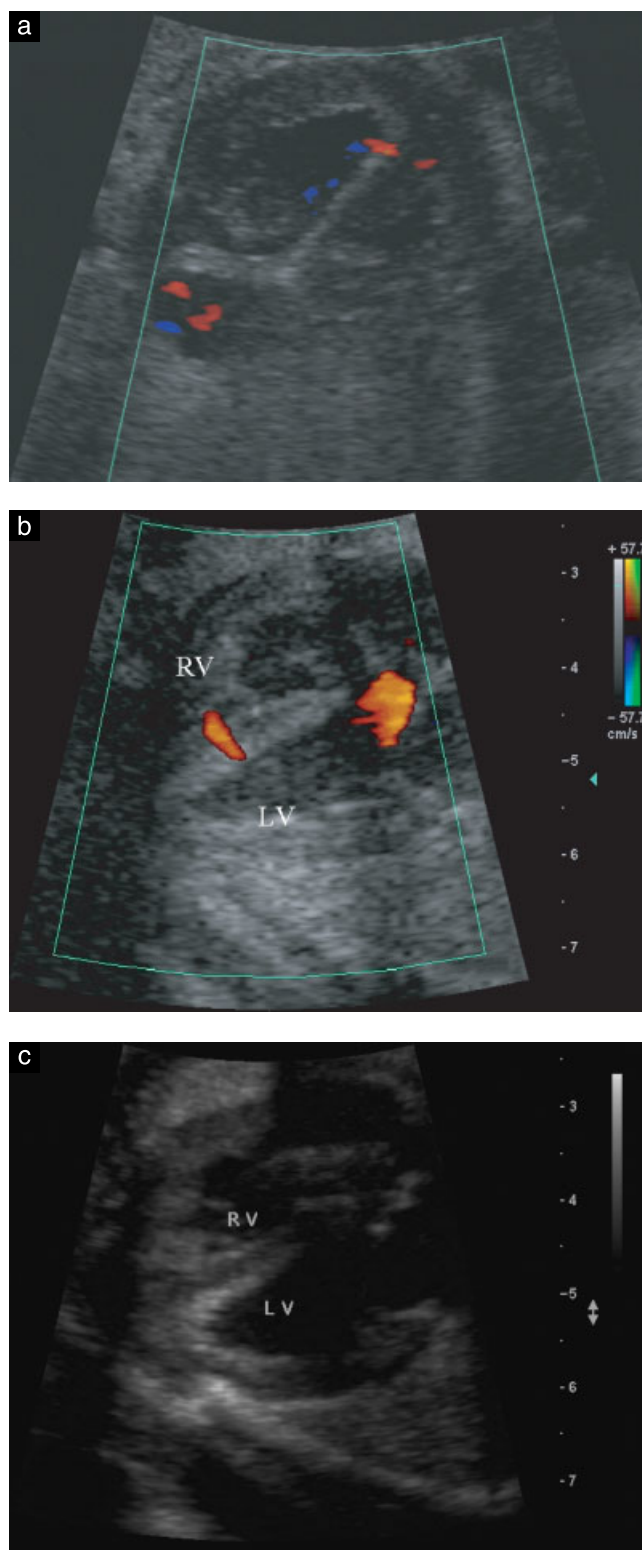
Color Doppler ultrasound images showing (a) small apical muscular defect, which closed during gestation, and (b) small mid-muscular trabecular defect, which closed during the first year of postnatal life. (c) Gray-scale image of the four-chamber view corresponding to that in (b). The small ventricular septal defect is not visible in this mode. LV, left ventricle; RV, right ventricle.
